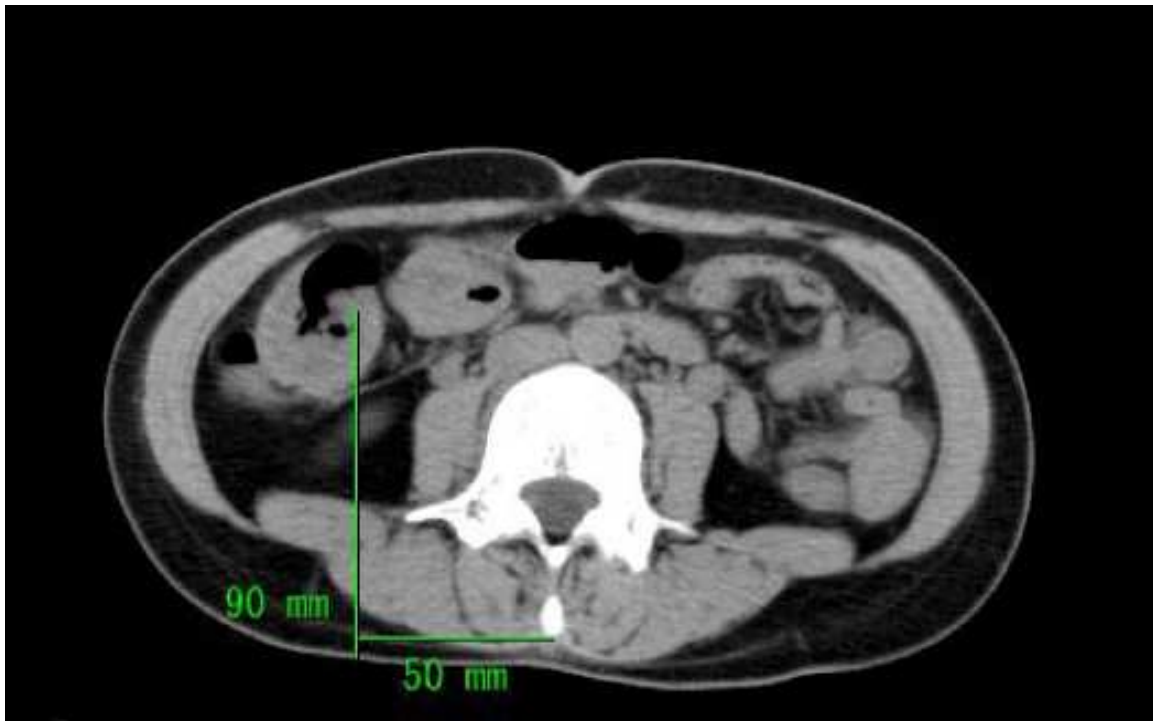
Computed tomography of the 4th lumbar spine level from a 37-year-old female.
